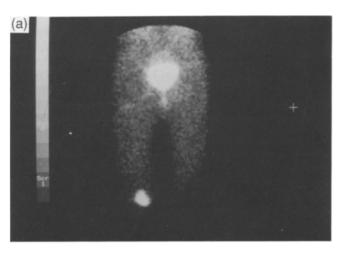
(a) Posterior ¹²³I mIBG scintigram showing abnormal isotope uptake in the medial aspect of the left femur (patient 8, assessment 1). (b) The T1-weighted (TR 500 ms, TE 17 ms) coronal MR scan showing an abnormal area of low marrow signal corresponding to the area of high isotope uptake. An aspirate from the distal femoral lesion demonstrated viable neuroblastoma (patient 8, assessment 1).
